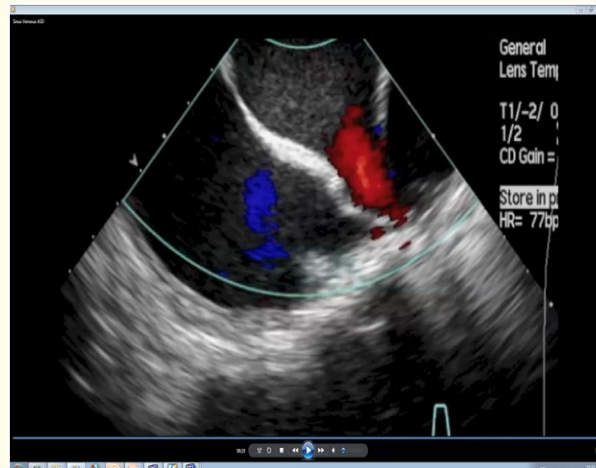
Postoperative transesophageal echocardiography image.
